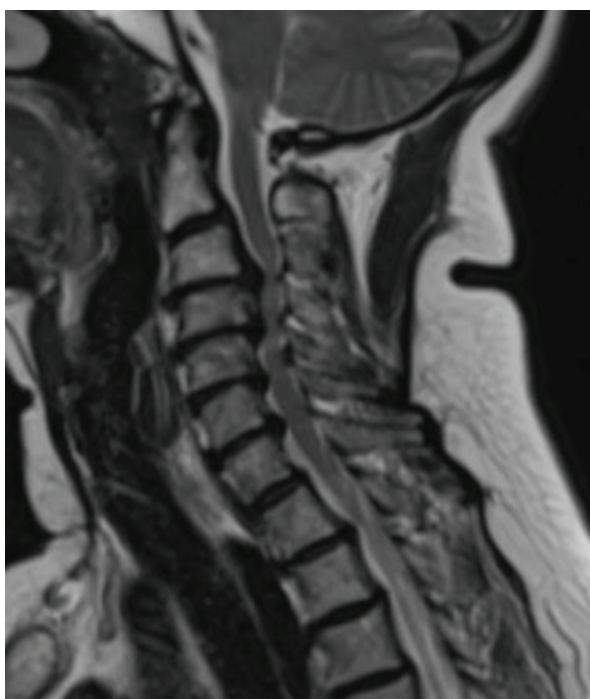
T2-weighted sagittal cervical MRI shows multiple disc herniations with multilevel OPLL and critical stenosis. Intramedullary T2 hyperintensity indicates severe myelopathy. Spinal canal morphology is severely compromised.
